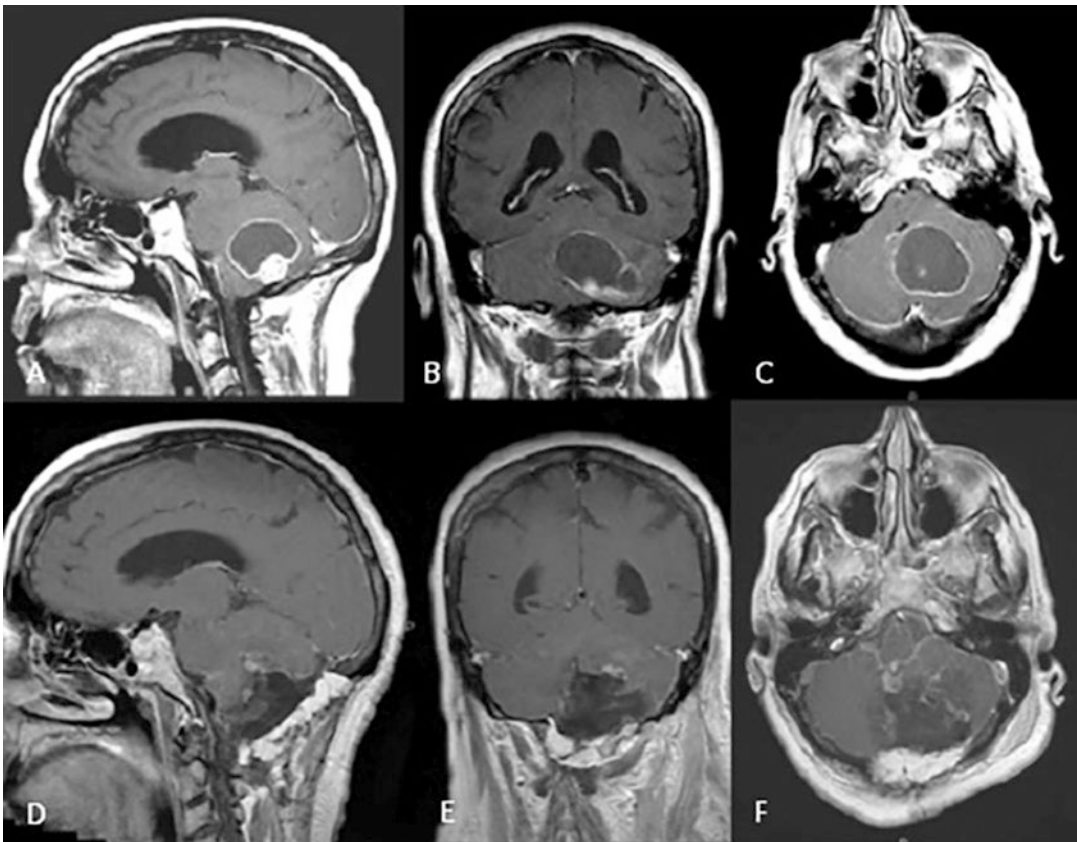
A 62-year-old female patient with dizziness and balance problems. Metastatic lung adenocarcinoma. (a) preoperative T1-weighted post-contrast MRI of the brain, sagittal view. (b) coronal view. (c) axial view. (d)
